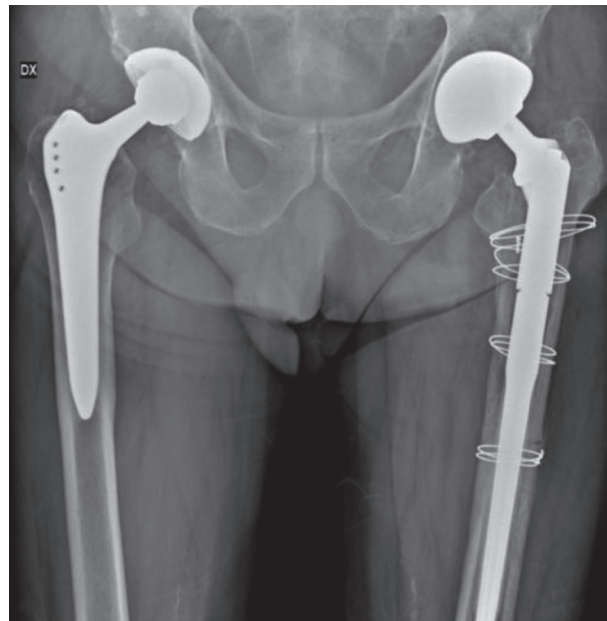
Case 2. Pelvic AP view post-operative radiographs showing implant revision of the left hip
